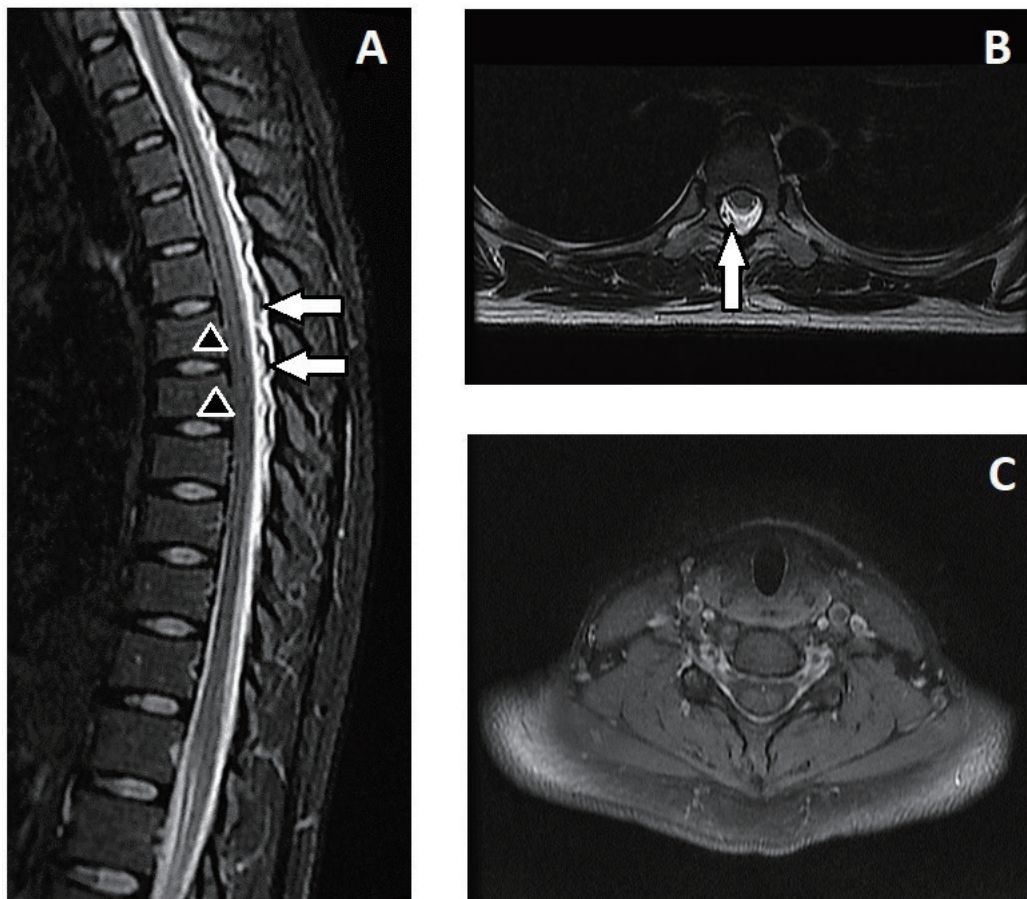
A 24-year-old female had orthostatic headache. A, Sagittal T2-weighted spine MR images showed dilated epidural veins (arrows) and ventral displacement of thoracic spinal cord (arrowheads). B, Dilated epidural veins in axial T2-weighted thoracic spine MR images (arrow). C, Axial T1-weighted spine MR images with gadolinium enhancement showed diffuse dural enhancement.
